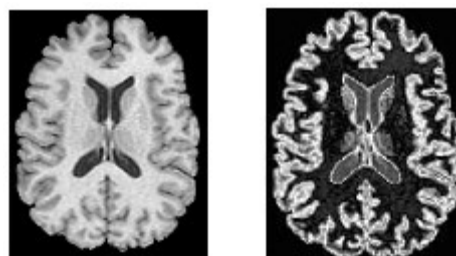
Original MRI image Figure 6. Image after Cluster 1
